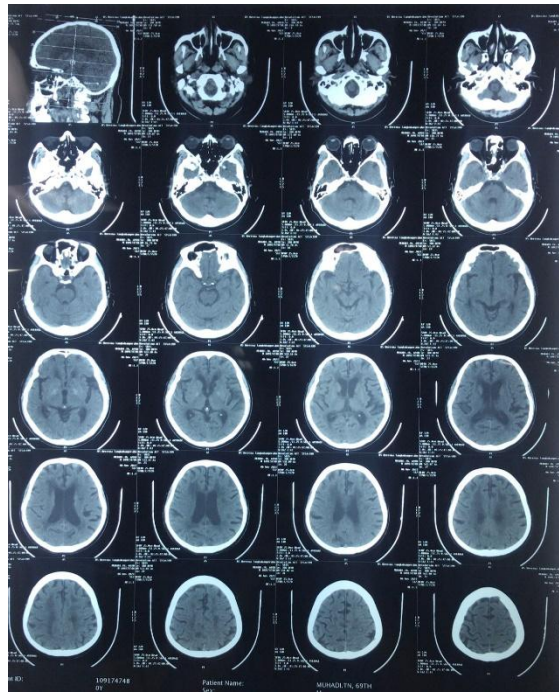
Head CT Scan showed acute infraction at lentiformis nucleus dextra and corona radiata dextra, chronic infraction at caudatus nucleus dextra et sinistra, and senile brain atrophy.
